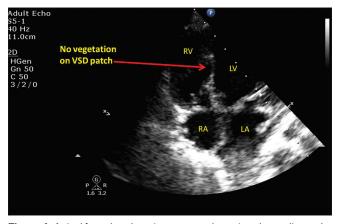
Apical four chamber view on transthoracic echocardiography examination showing no vegetation after 8 weeks of antifungal therapy on the PTFE patch (red arrow) in apical four chamber view on transthoracic echocardiography examination. PTFE: Polytetrafluoroethylene, LA: Left atrium; LV: Left ventricle; RA: Right atrium; RV: Right ventricle
